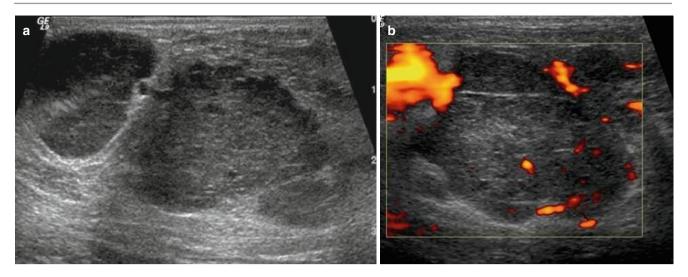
(a, b) A 35-year-old woman during lactation with a painful lump associated with mastitis. (a, b) Ultrasound demonstrates a complex fluid collection consistent with an abscess
